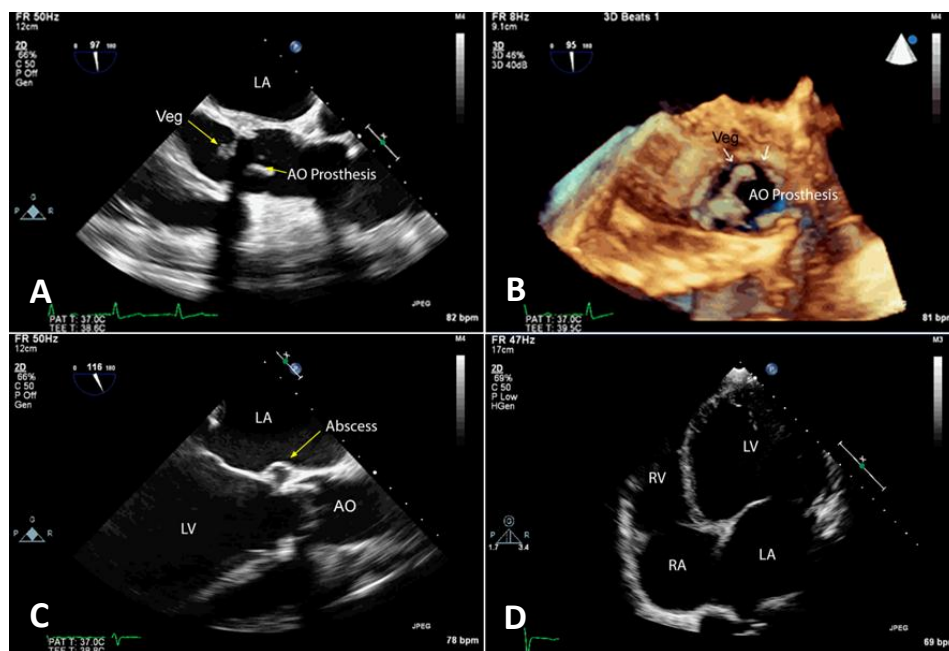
Transesophageal and transthoracic echocardiogram (TEE and TTE, respectively) in a patient with Marfan syndrome. A. Esophagus incised at 120° showing vegetation (Veg) adhered to the cusps of the aortic biological prosthesis (AO Prot); B. Three-dimensional base vessel transverse section TEE showing vegetation adhered to the leaflets of the aortic prosthesis; C. TEE of the middle esophagus at 120° showing the abscess of the mitro-aortic junction; D. TTE of the apical position of the 4 chambers showing left ventricular and atrial dilatation due to systolic function deficit. LV: left ventricle; RV: right ventricle; LA: left atrium; RA: right atrium.
